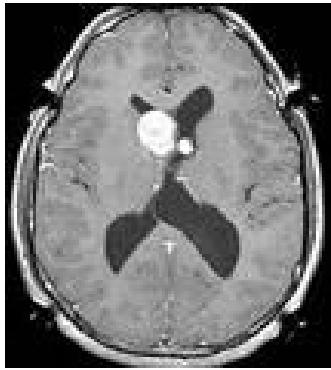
MRI in patient with tuberous sclerosis
